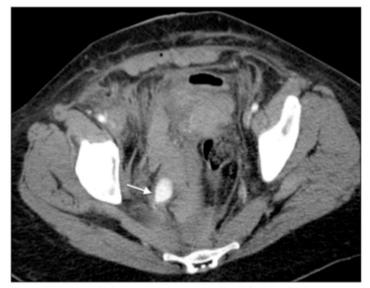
CTA demonstrates a vascular "blush" of a 2cm
